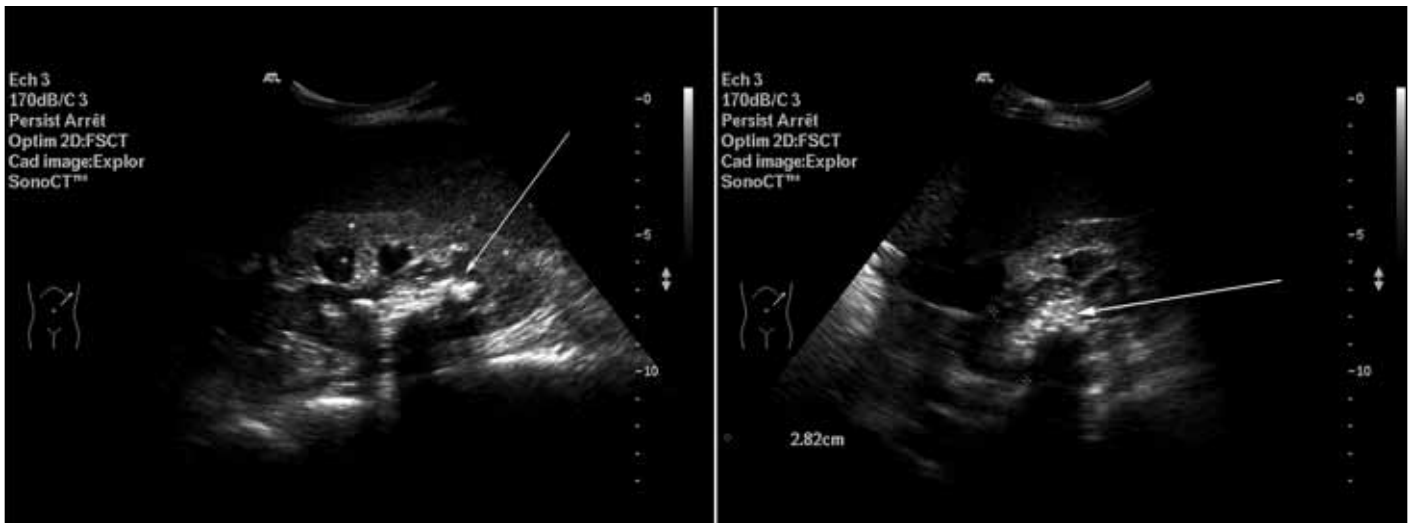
Ultrasound analysis revealed bilateral hydronephrosis with pyelic hyperechogenic material.
